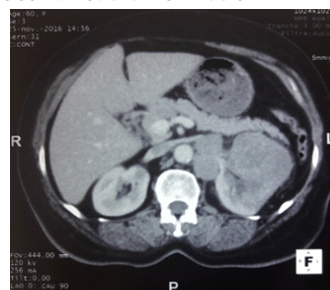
Computed tomography scan showing a left kidney mass
